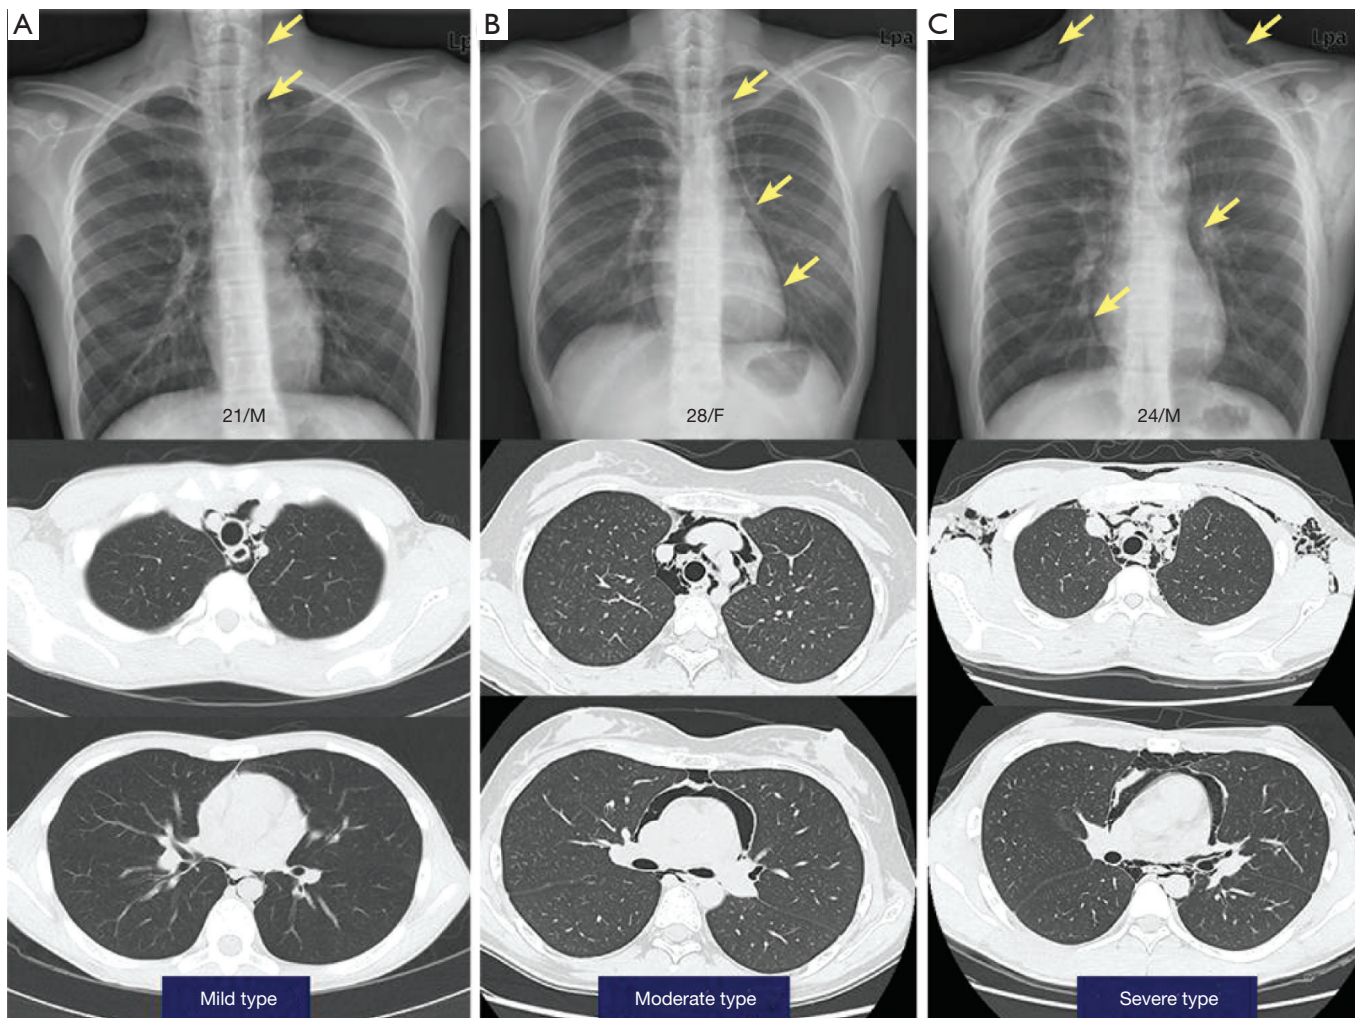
Representative appearance of spontaneous pneumomediastinum in initial chest X-ray and chest computed tomography by simple classification. Mild type (A), moderate type (B) and severe type (C).
